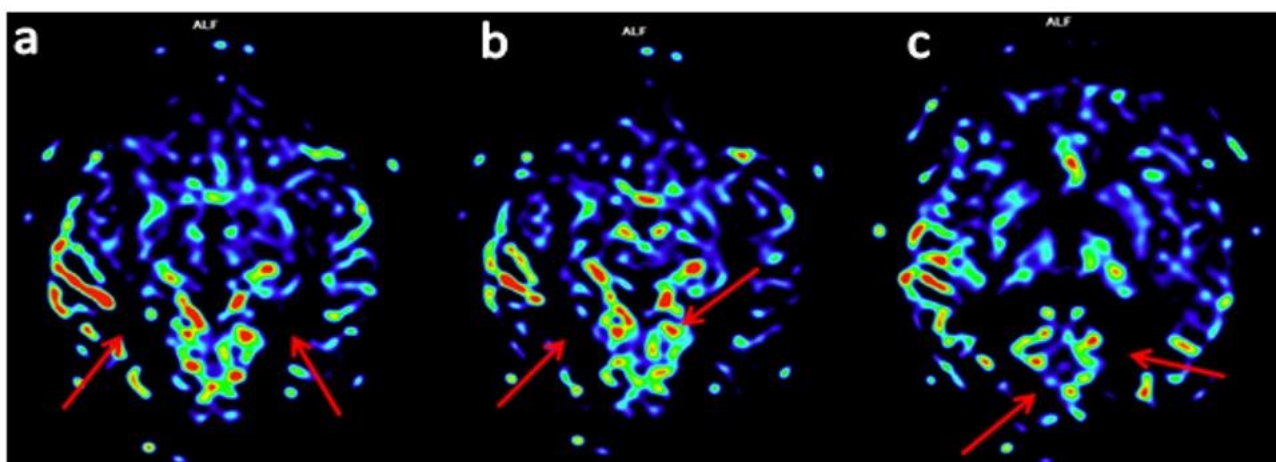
(a, b, c): MRI brain fused ASL images depicting bilateral occipital regional hypoperfusion with preserved perfusion of posterior cingulate cortex (arrows) giving “CINGULATE ISLAND SIGN”.
